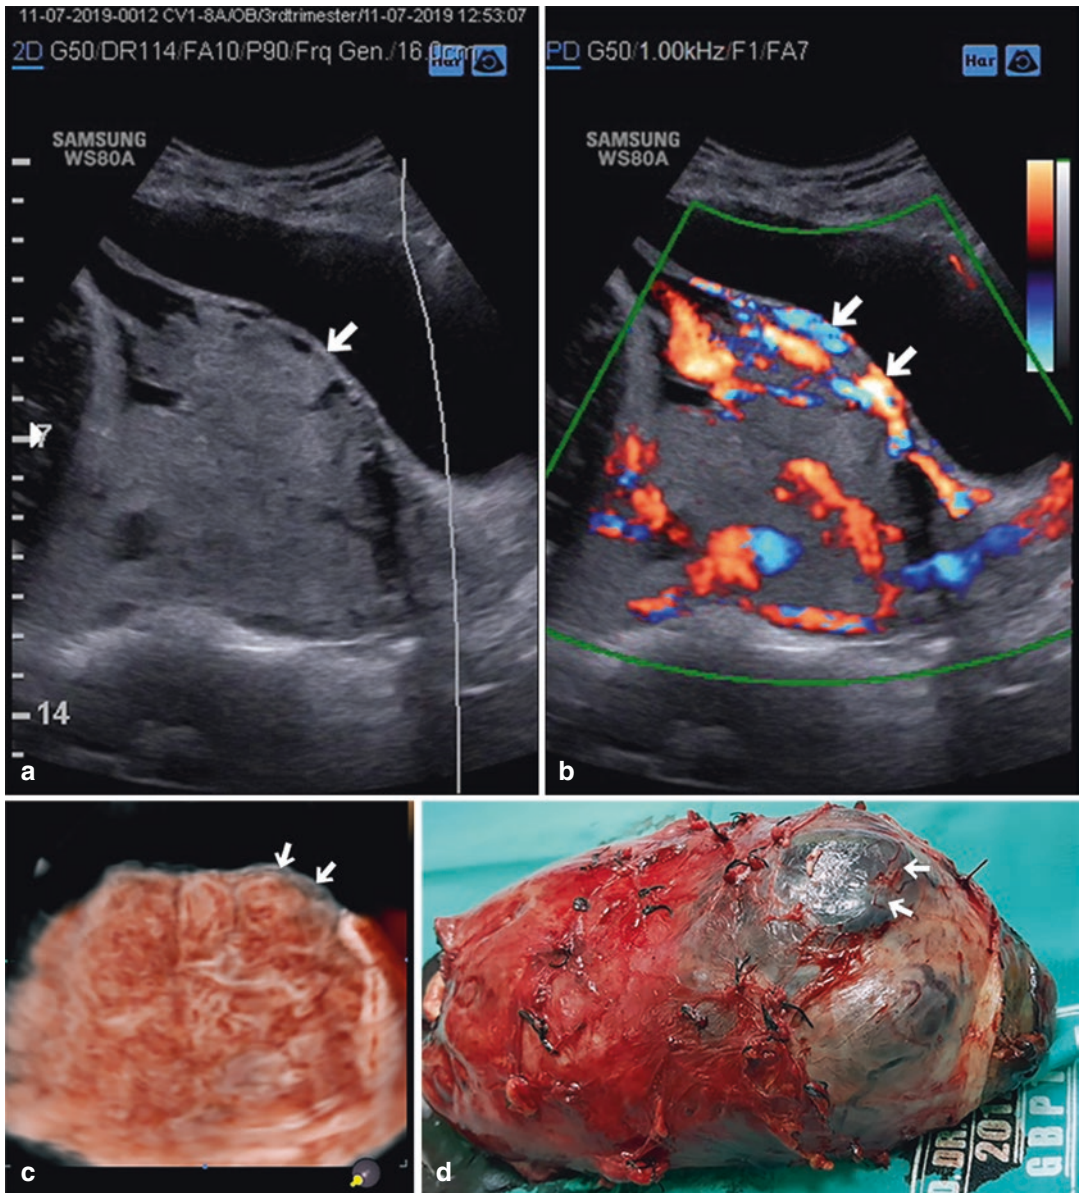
(a) Placental Bulge (arrow) in Transabdominal 2D Ultrasound with (b) uterovesical hypervascularity (arrow) that analyze using 3D volume rendering ultrasound (c) in the same ultrasound probe plane shows highly suspicious of placenta percreta invasion (arrow) that proven (d) during surgery (arrow)
